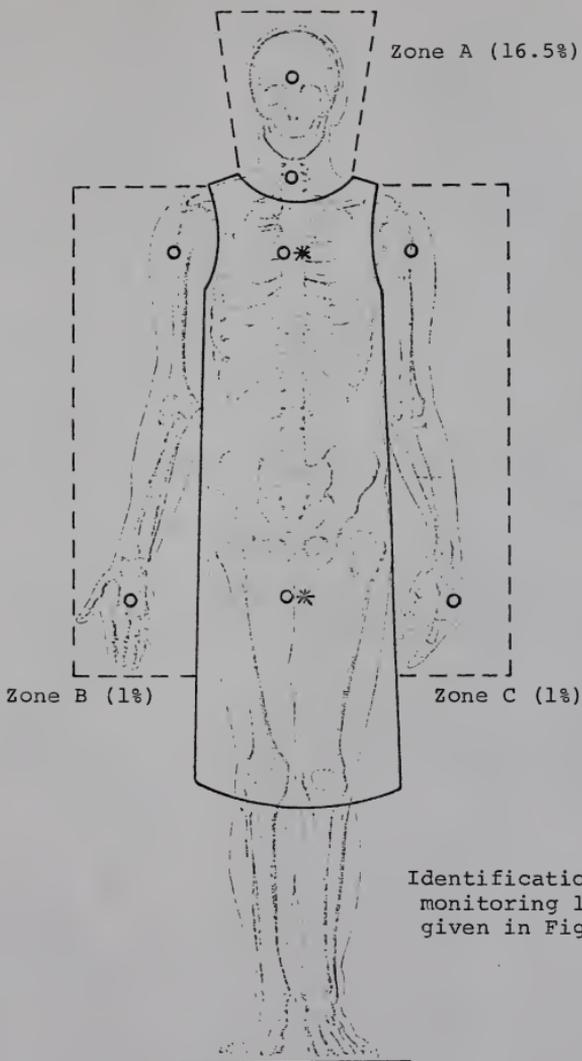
Subdivision of Body of X-ray Operational Personnel Wearing Lead Apron with Identification of Active Bone Marrow Fractions.
